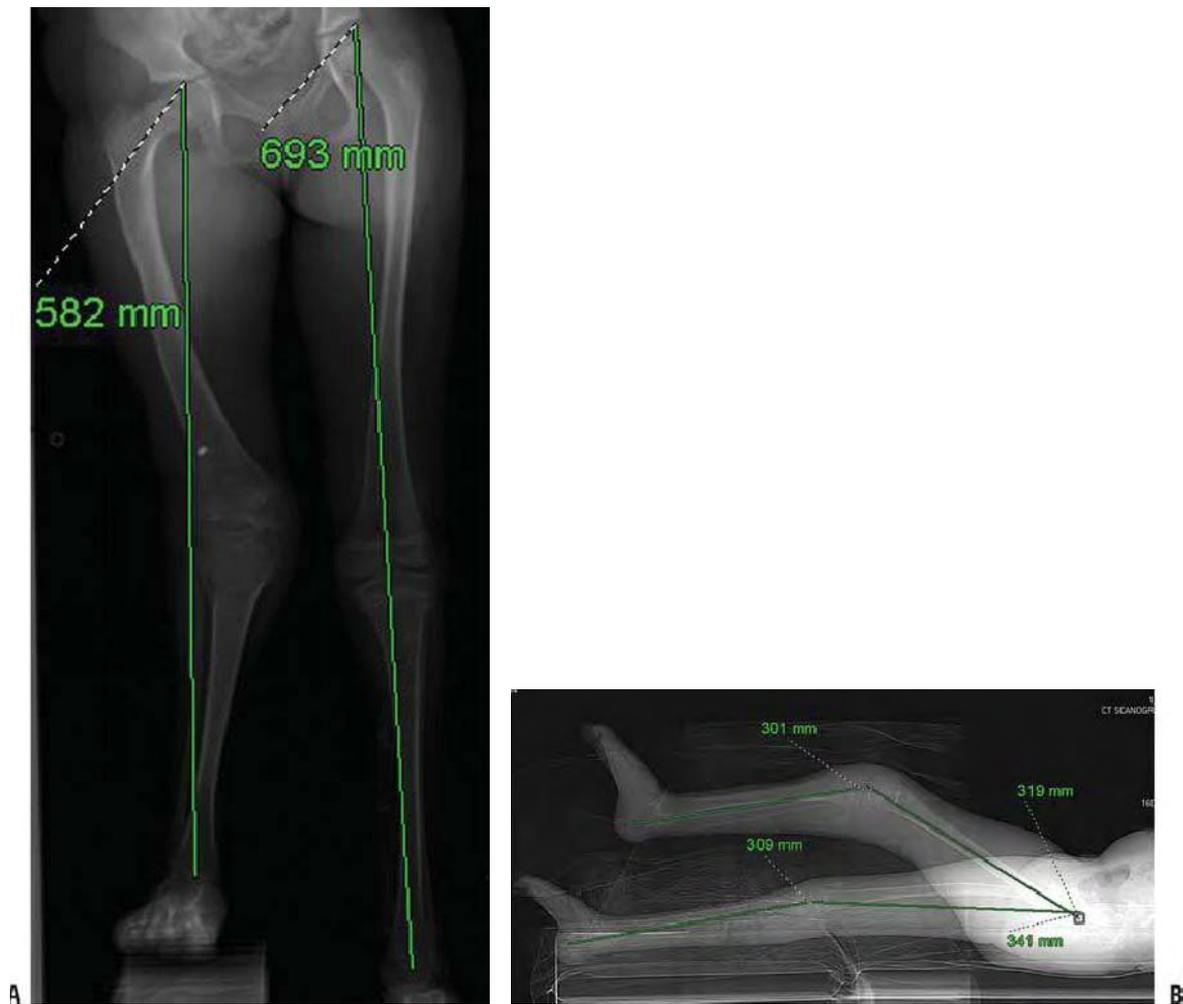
A: Standing alignment film of an 11-year-old girl with arthrogyrosis demonstrates a functional discrepancy in length approximating 9 cm. Unfortunately, her severe knee flexion contracture precludes accurate assessment of her anatomic bone lengths. B: Lateral CT scanogram demonstrates that her femur is not significantly shortened (2 cm) and her tibia are essentially equal.
